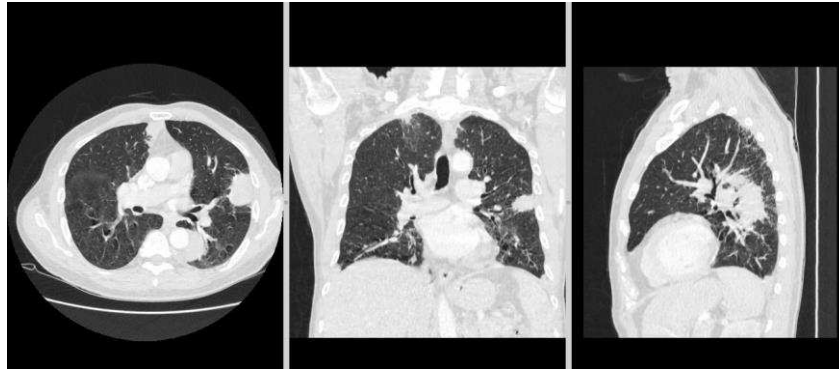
A 67-year-old man with pulmonary LNH on a chest CT scan with contrast, showing a mass in the lung with spiculated edges
